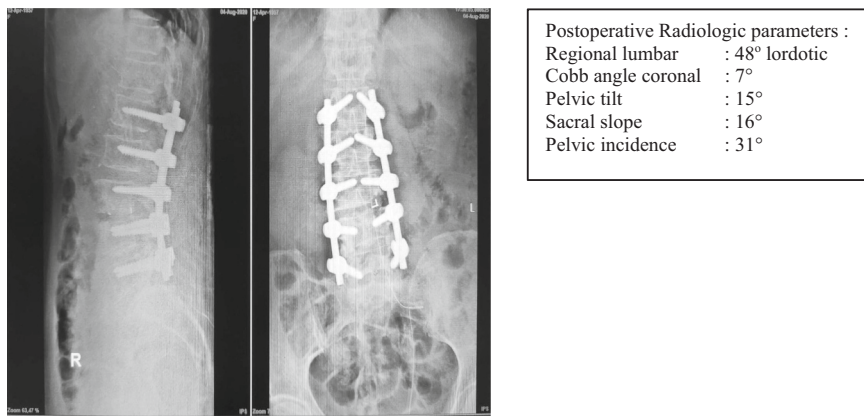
Case 5 Postoperative radiograph.
